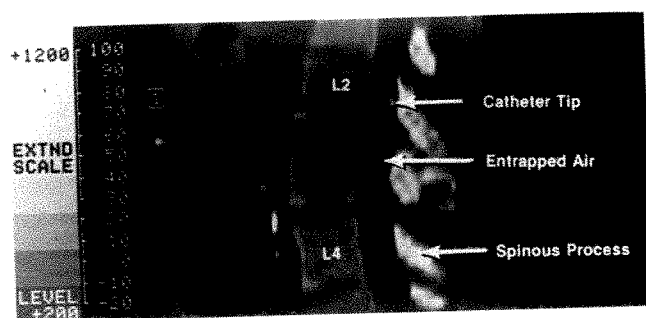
Longitudinal CT scan of lumbar spine demonstrating epidural air.
